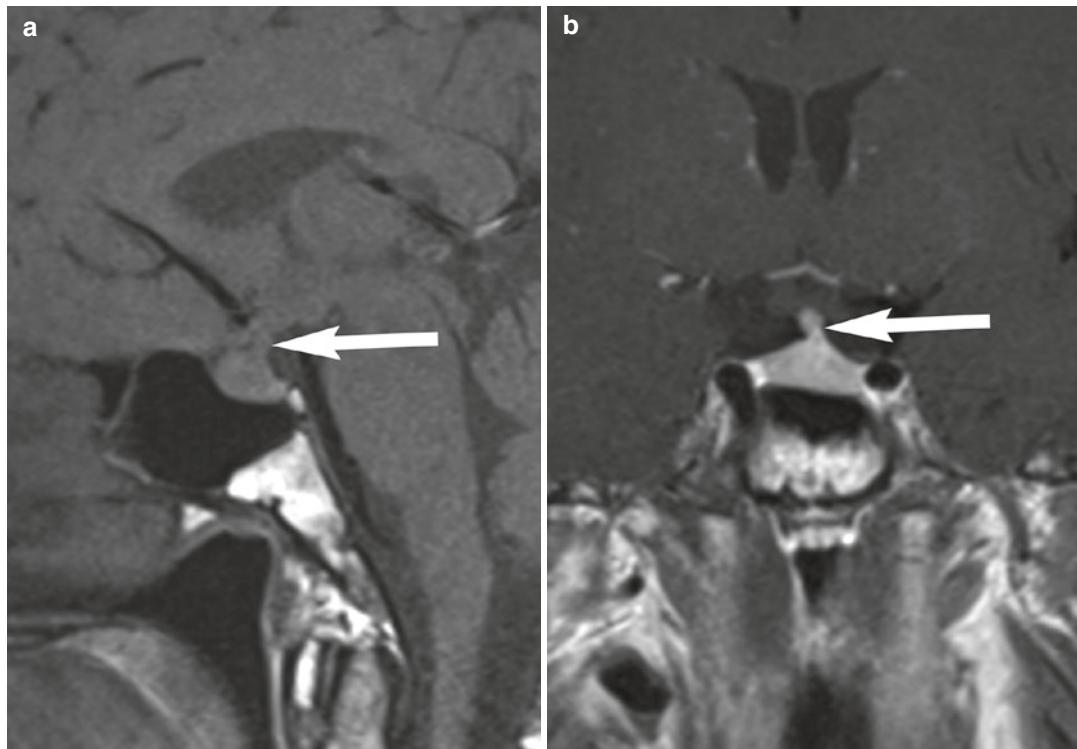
Lymphocytic hypophysitis. A 32-year-old post-partum female with symptoms of hypopituitarism. Sagittal (a) unenhanced T1-weighted image shows thickening of the infundibular stalk (white arrow). On coronal (b)
